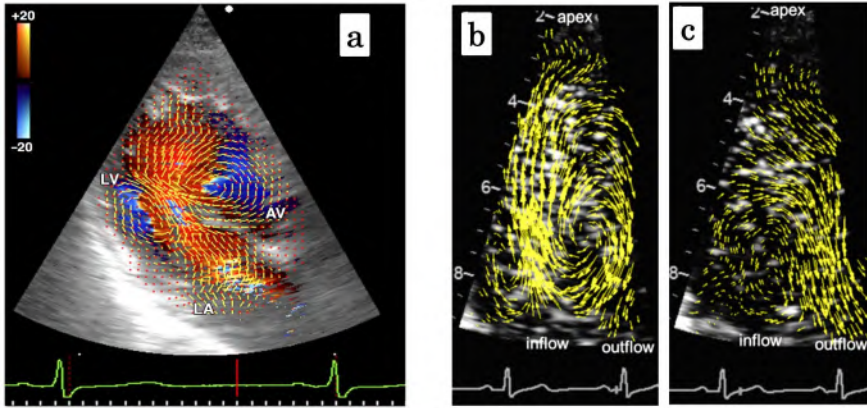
left:* VFM velocity and vorticity map by using cross-sectional image obtained by bi-mode color Doppler and speckle tracking information (Image courtesy of Tokuhsa Uejima, Cardiovascular Institute, Tokyo, Japan). *Right:* Echo-PIV, velocity vector maps at early diastole and ejection phase (adopted from [7]).
